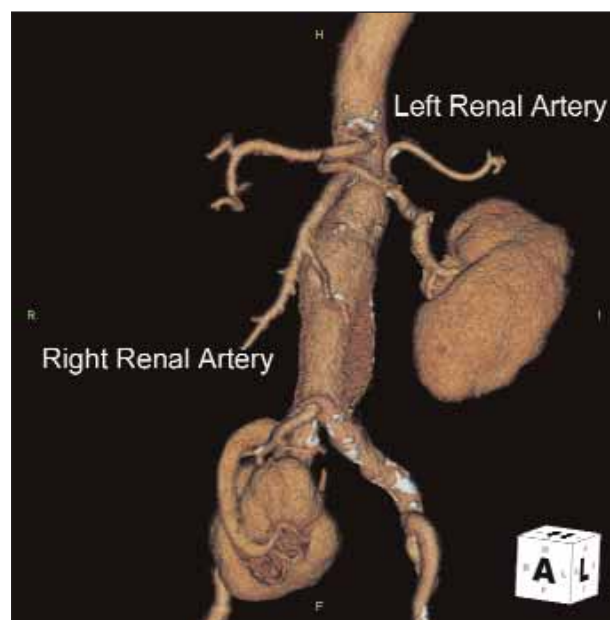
A preoperative CT scan revealed a right pelvic kidney and considerable iliac calcification. Three-dimensional images were constructed using TeraRecon software.
